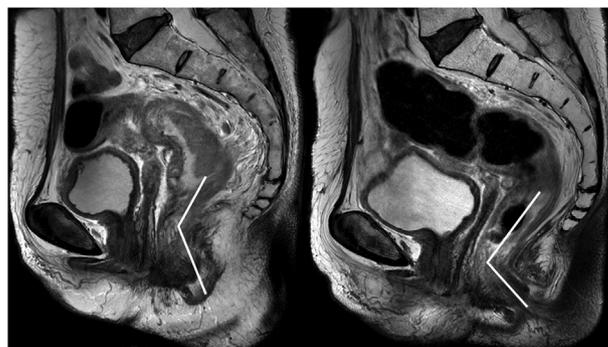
Tumor height measurements. Tumor height in MRI was measured from anal verge to the lower margin of the tumor at the initial MRI (left) and after completion of preoperative chemoradiotherapy (right) in same patient.
